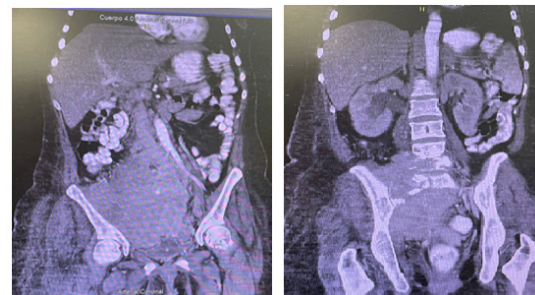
Voluminous image of density of soft parts in hypogastric region and right iliac fossa of 143 x 137 mm in contrasted abdominal CT (A). Right hydronephrosis and bone cortical involvement generating lysis of the right sacral aleron and lytic-looking images in the vertebral body of D2, L1, L4 and L5 (B).
